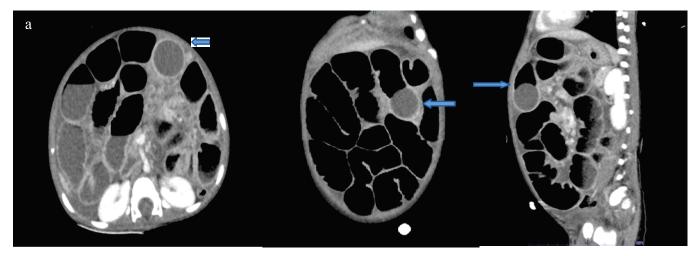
CT abdomen and pelvis showed the small bowel obstruction with spherical foreign body.
